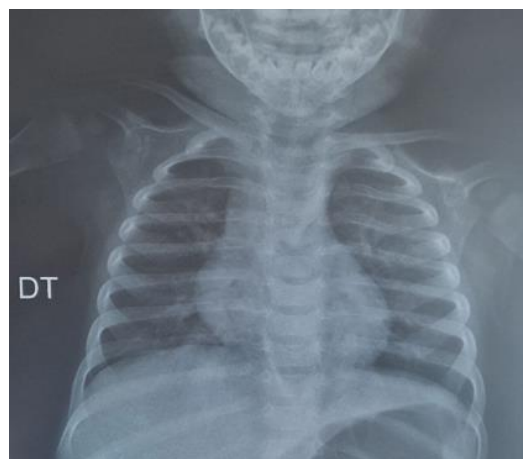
Normal chest X-ray of the patient
